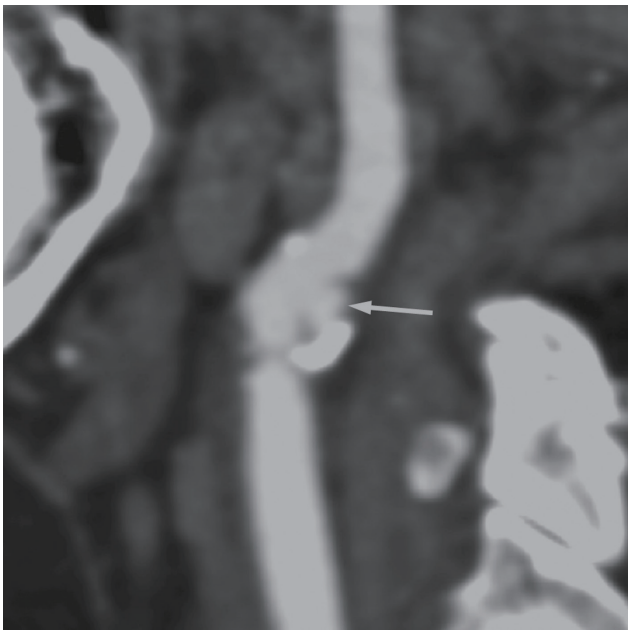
Computed tomography angiographic image showing ulcerated plaque (arrows) with calcification in the carotid artery.
